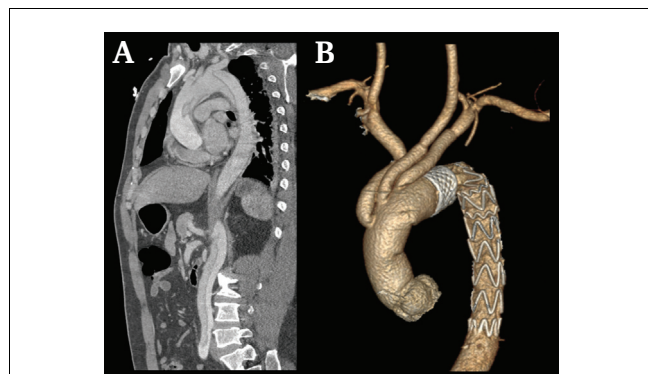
(A) Pre-operative oblique sagittal view of aortic computed tomography angiogram (CTA) shows DeBakey type I aortic dissection. (B) Post-operative 3D reconstruction of aortic CTA shows the appearance of the sutureless integrated stented (SIS) graft.
